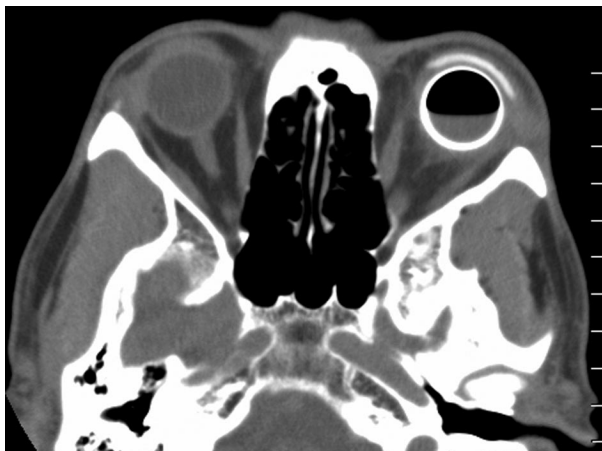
Axial CT. Soft tissue changes consistent with inflammation and cellulitis are visible around the implant in the left orbit. The hollow glass sphere is readily visible with its internal air-fluid level.
